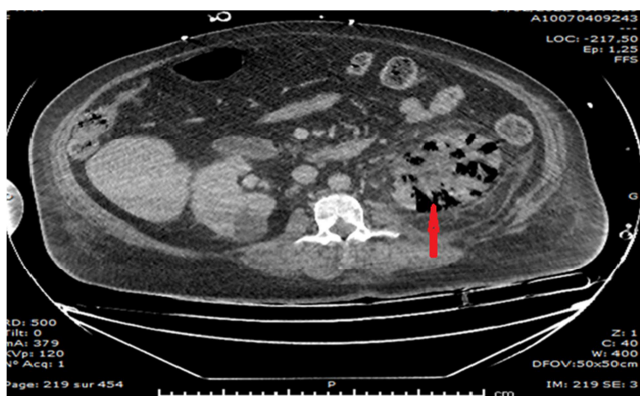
CT scan of multiple emphysematous ANP of the left kidney.
